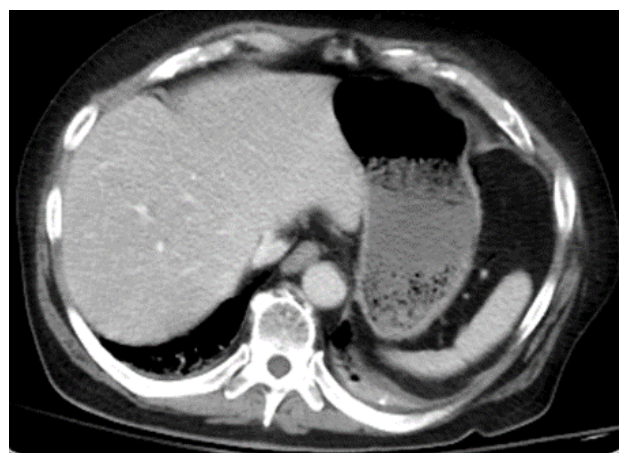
Repeat CT scan that shows persistent gastric pneumatosis with resolution of pneumobilia
